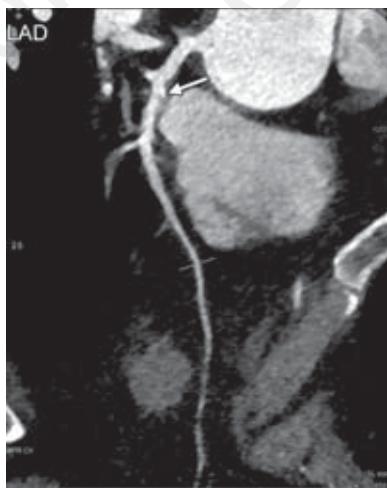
Computed tomography angiography image showing mild disease with eccentric calcific plaque in proximal left anterior descending artery (arrow).
